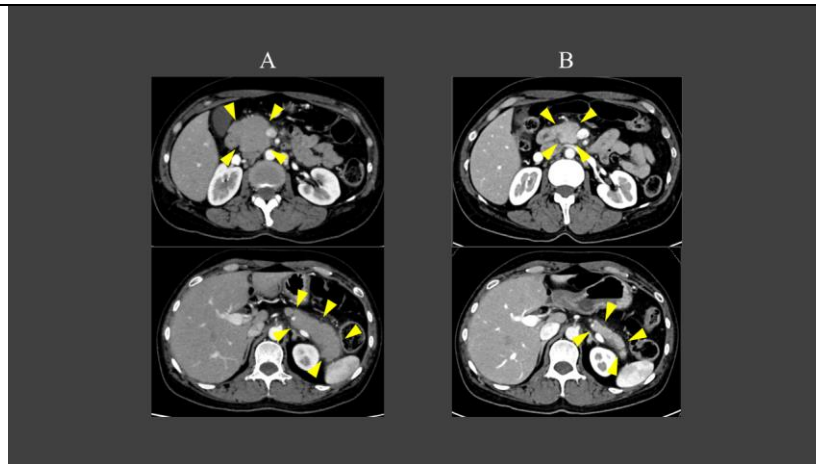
A) contrast-enhanced computed tomography (CE-CT) at the initial visit, B) CE-CT two months later. CT scan showed marked improvement in pancreatic enlargement (arrowheads).
